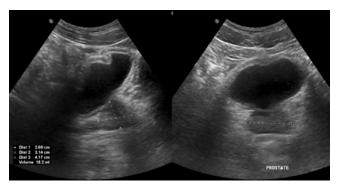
Example of measurement of prostate volume on transabdominal ultrasound in a 40-year-old man
